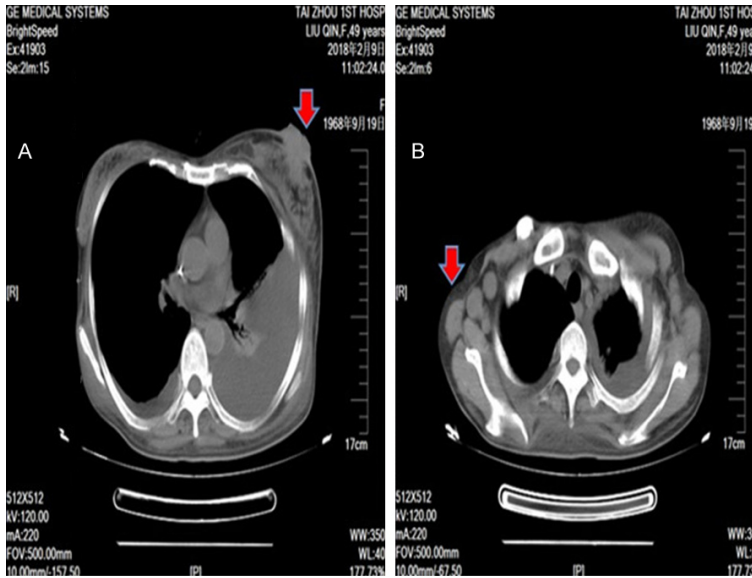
The chest computed tomographic scan showing before radiotherapy in (A and B). (A) An irregular tumoral lesion of the left breast (red arrow) and bilateral pleural effusion, especially in the left. (B) Multiple right lymph node enlargements (red arrows).
